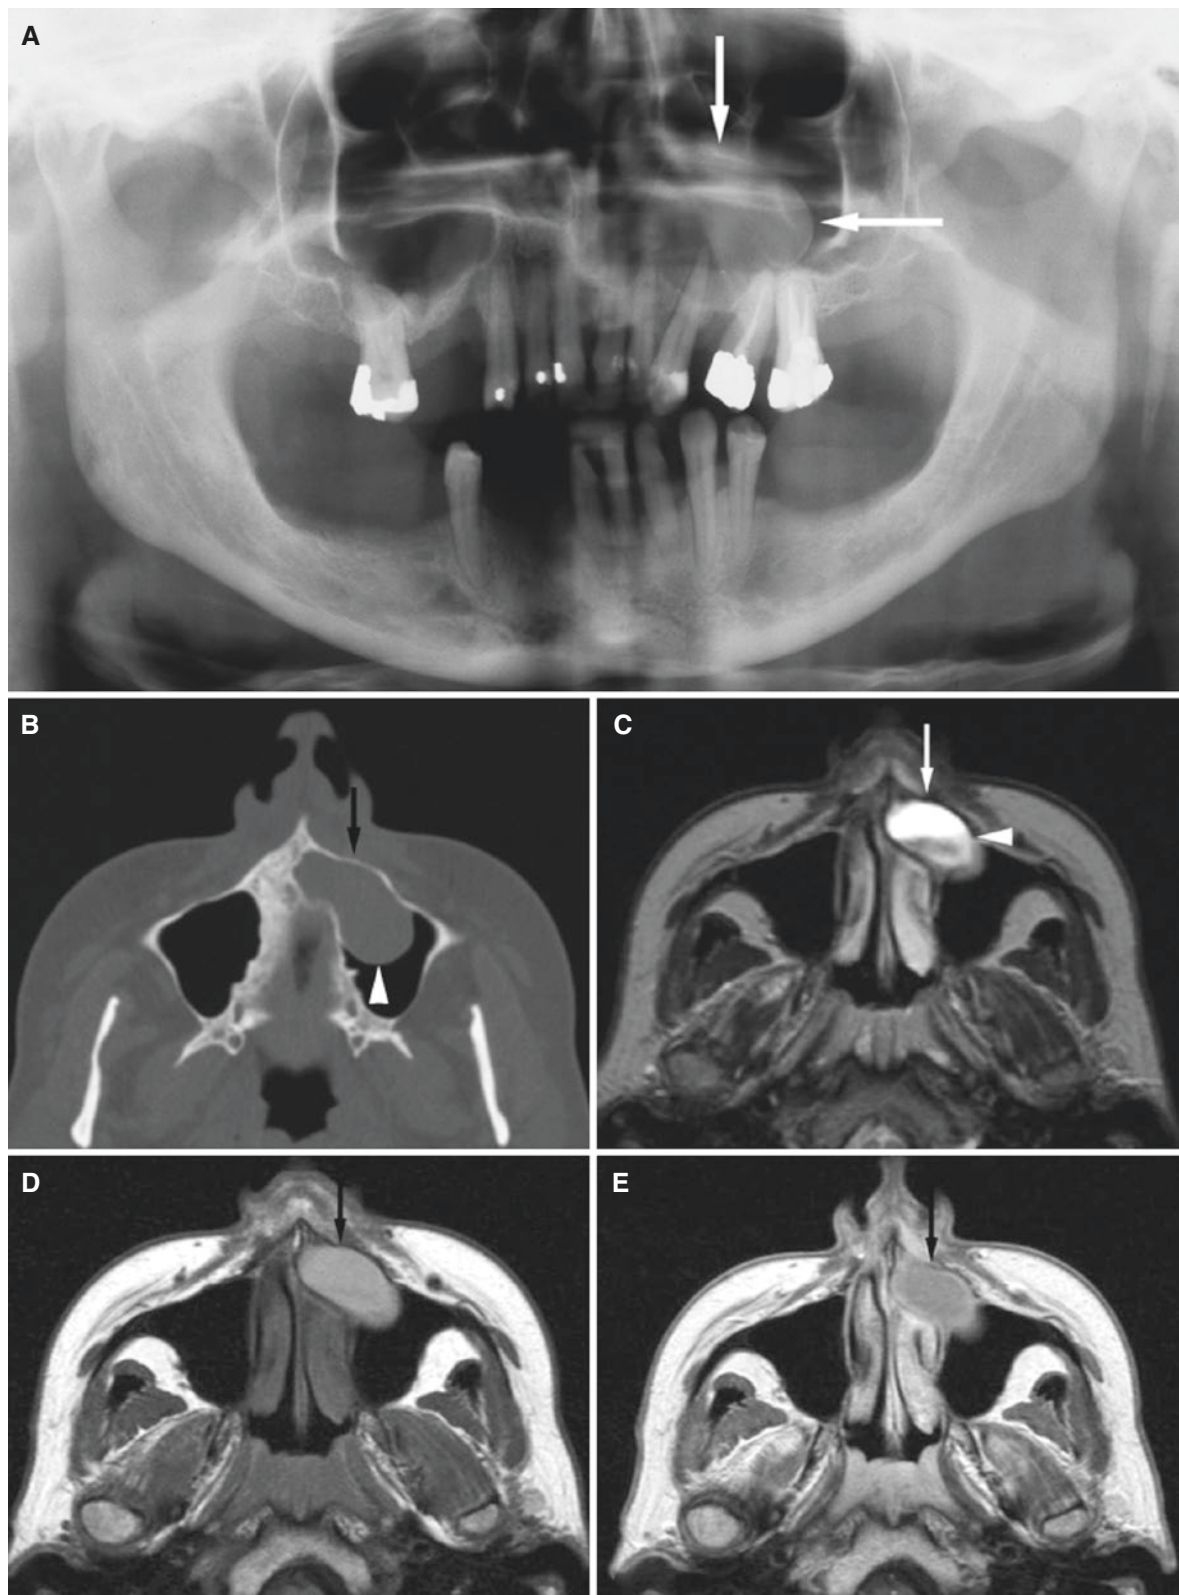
Periapical cyst, maxilla; 45-year-old female with incidental finding at routine dental radiography, nonvital left lateral incisor. (A) Panoramic view shows round process (more dense than air) with sclerotic border (arrows). (B) Axial CT image shows expansive process (arrow) with intact sclerotic border in the maxillary sinus (arrowhead).
